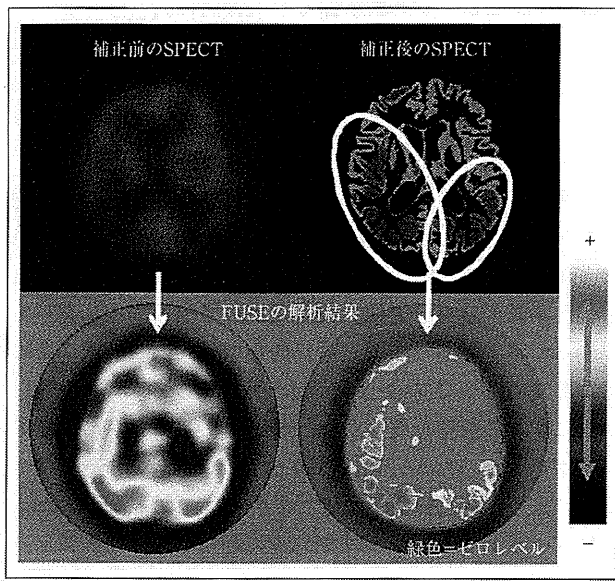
部分容積効果補正前と補正後のSPECT画像とFUSEによる解析結果
